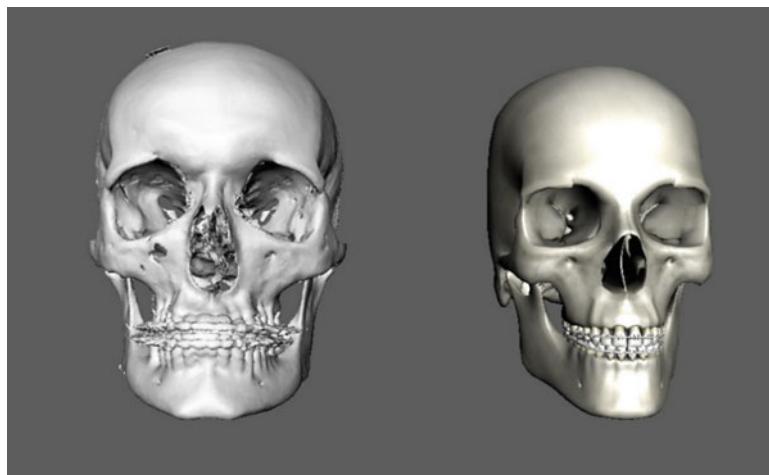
3D surface model generated from CT scanned data (*left*) and 3D model of skull modelled in Autodesk Maya (*right*)
